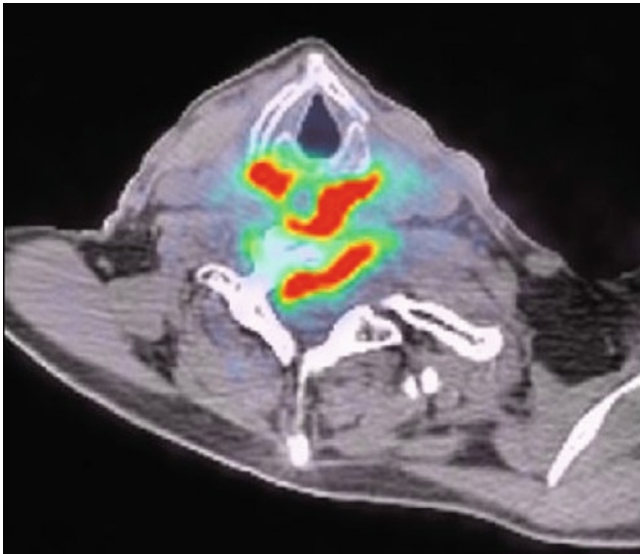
PET-CT image of a posterior pharyngeal wall cancer with invasion of the prevertebral fascia and bone of the cervical spine
